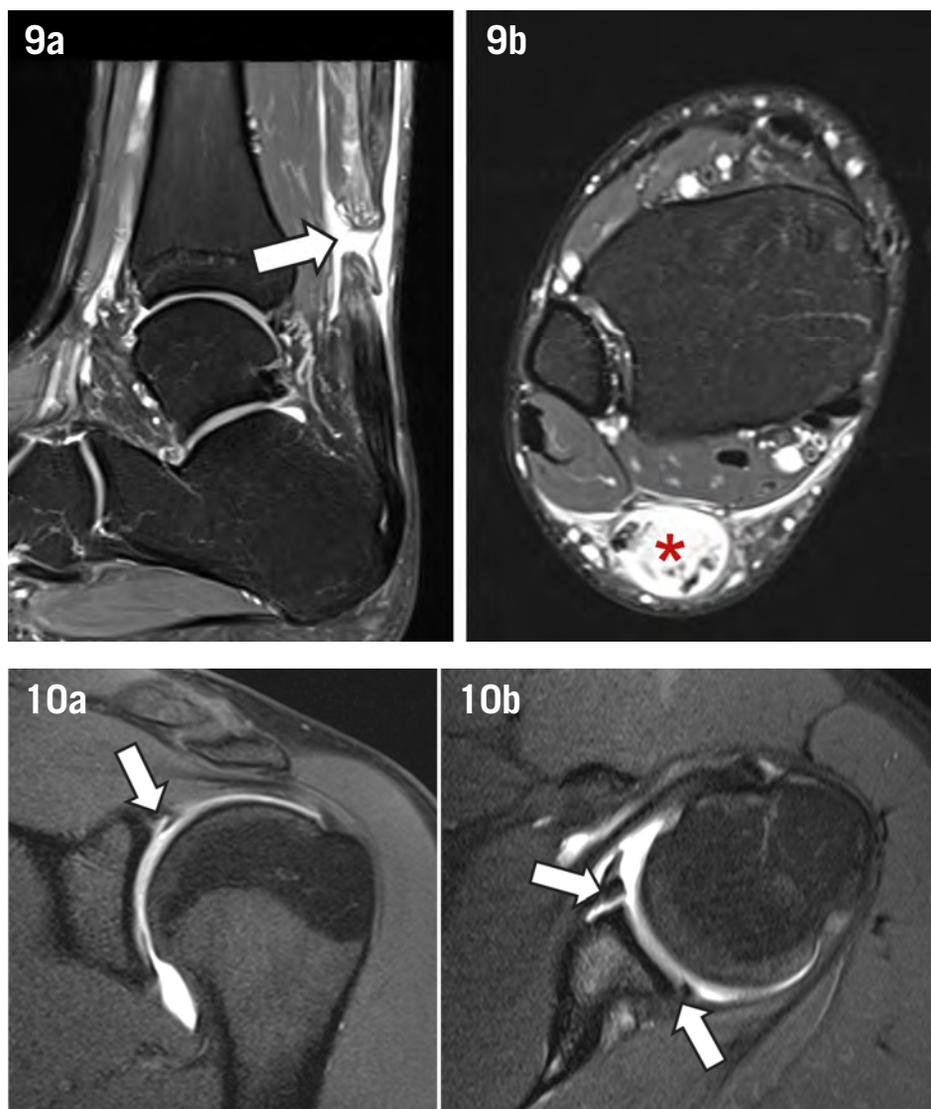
Magnetic resonance imaging of a complete tear of the Achilles tendon. Sagittal (a) and axial (b) T2 weighted images with fat saturation depicting a full-thickness tear of the Achilles tendon in the non-insertional segment (arrow) with a hematoma (asterisk) interposed in the tear and limited by the paratenon.
